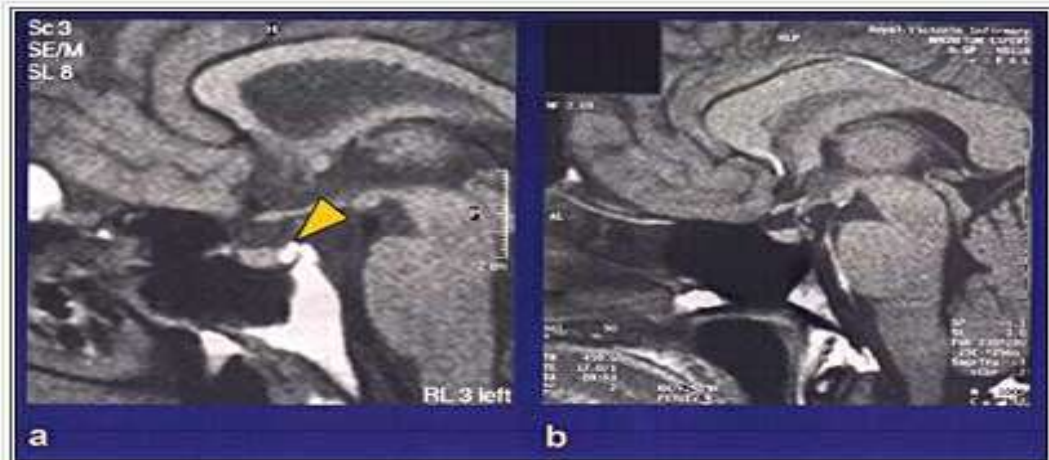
Loss of the posterior pituitary 'bright spot' on T1 weighted MRI in hypothalamic diabetes insipidus. The normal posterior pituitary can be demonstrated as a 'bright spot' within the sella turcica on T1-weighted MRI (a). This increased signal intensity can be lost in HDI (b). An ectopic posterior pituitary 'bright-spot' can be seen some cases of childhood onset hypopituitarism, implying failure to complete normal developmental migration. Function can be normal despite the aberrant position
